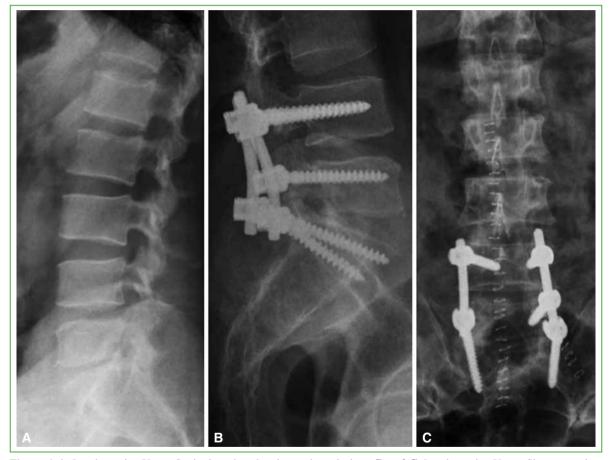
A. Lumbar spine X-ray. Sagittal section showing no bone lesions. B and C. Lumbar spine X-ray. Short posterior fixation of L4-L5-S1 (April 2011).
